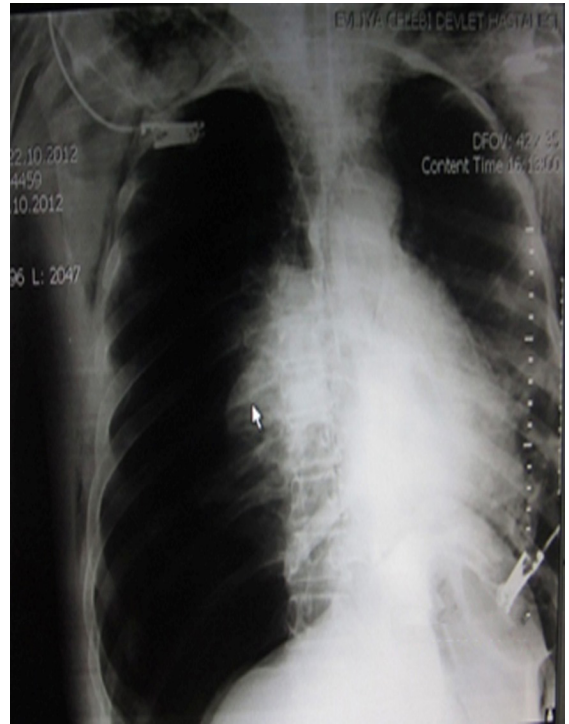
Thorax CT confirmed right-sided total, left-sided partial pneumothorax and massive SE. Tube thoracostomy was performed initially in the right lung.
